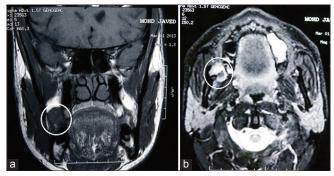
(a) MRI shows a well-defined lesion of 1.8 x 1.6 cm in the right retromolar trigone. T1 weighted image showing hypointense signal. (b) lesion appear as hyperintense signal on STIR (short TI inversion recovery) image
